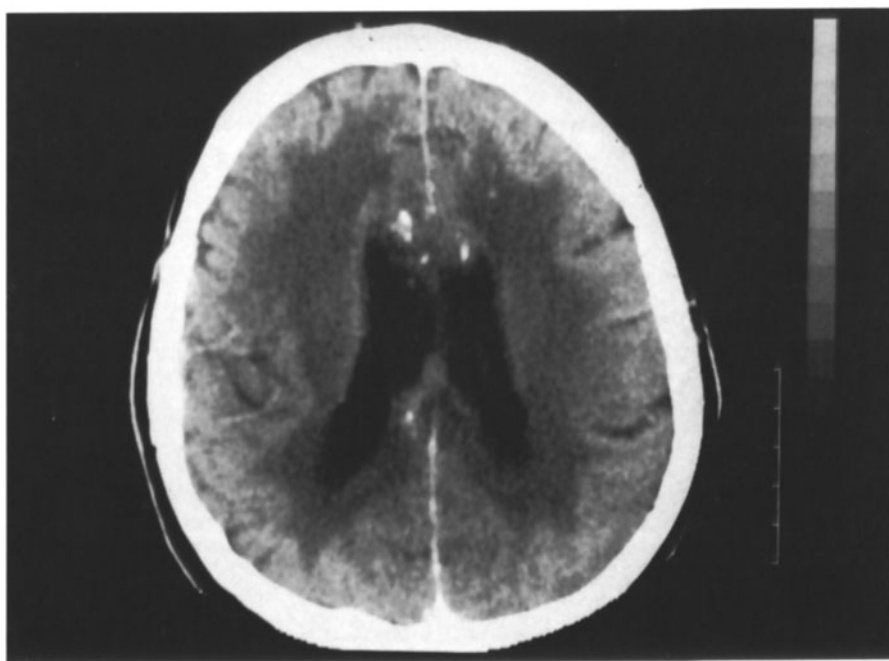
Delayed leukoencephalopathy after radiotherapy with unconventional fractionation, computed tomography (CT) scan
